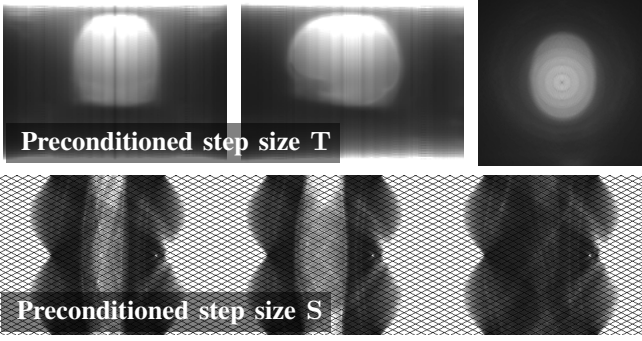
Preconditioned parameters \mathbf{T} (top) and \mathbf{S} (bottom) (14) for the data set FDG. Besides the boundary the step sizes are large in interesting regions clearly showing the head of the patient.
